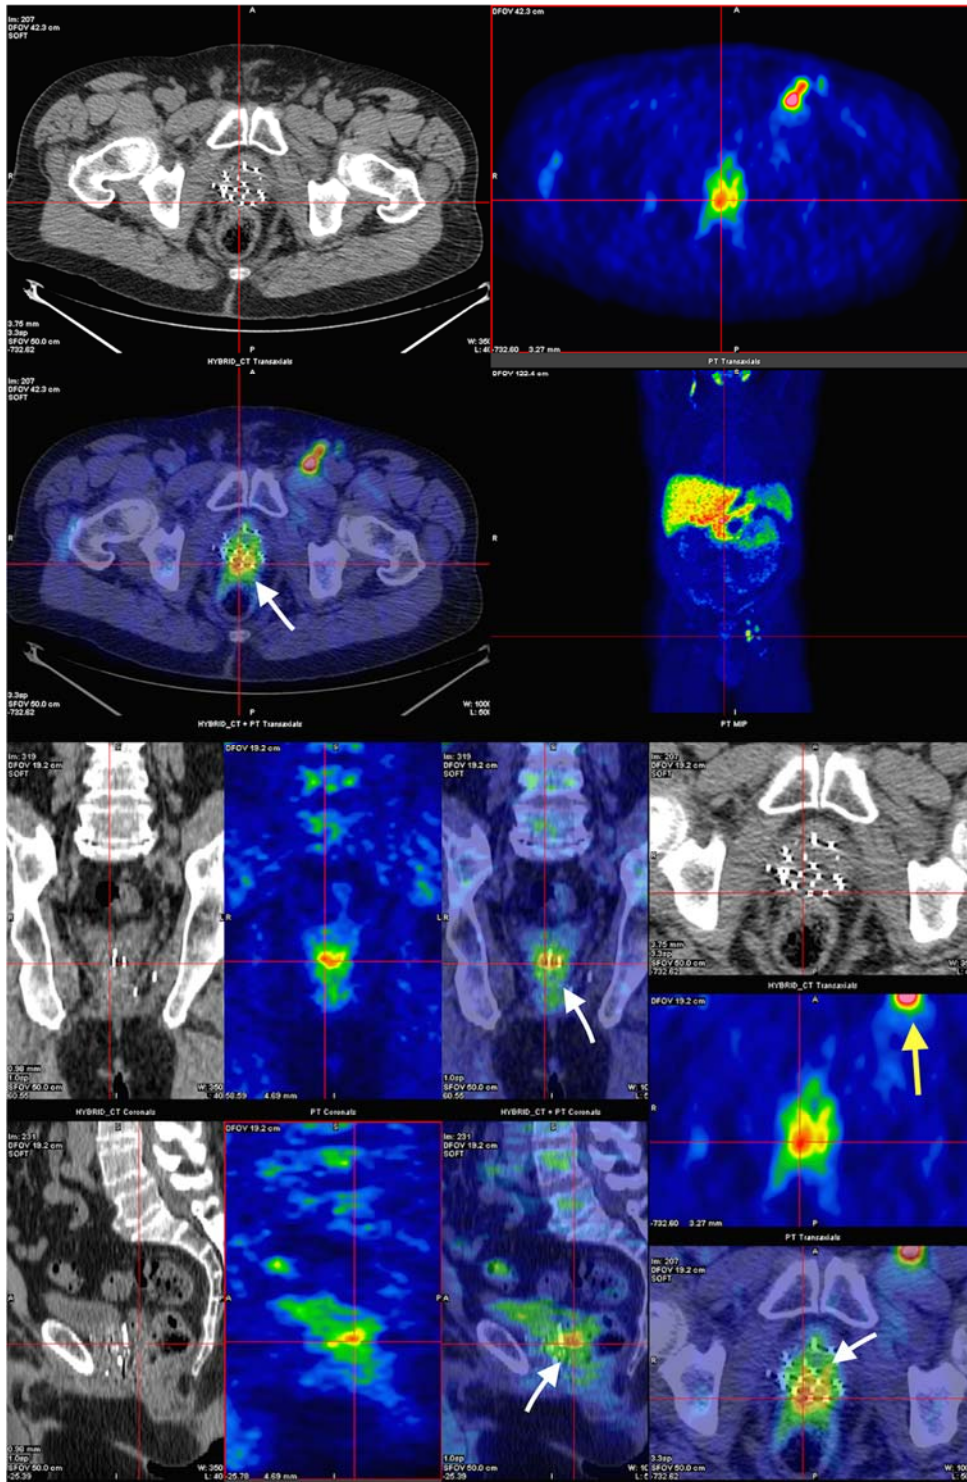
Fused PET/CTAC images demonstrating increased metabolic activity in the posterior region of the prostate at the interface of the anterior wall of the rectum (white arrows) (SUV_{max} 3.92), as well as spread to the left inguinal node (yellow arrow).
